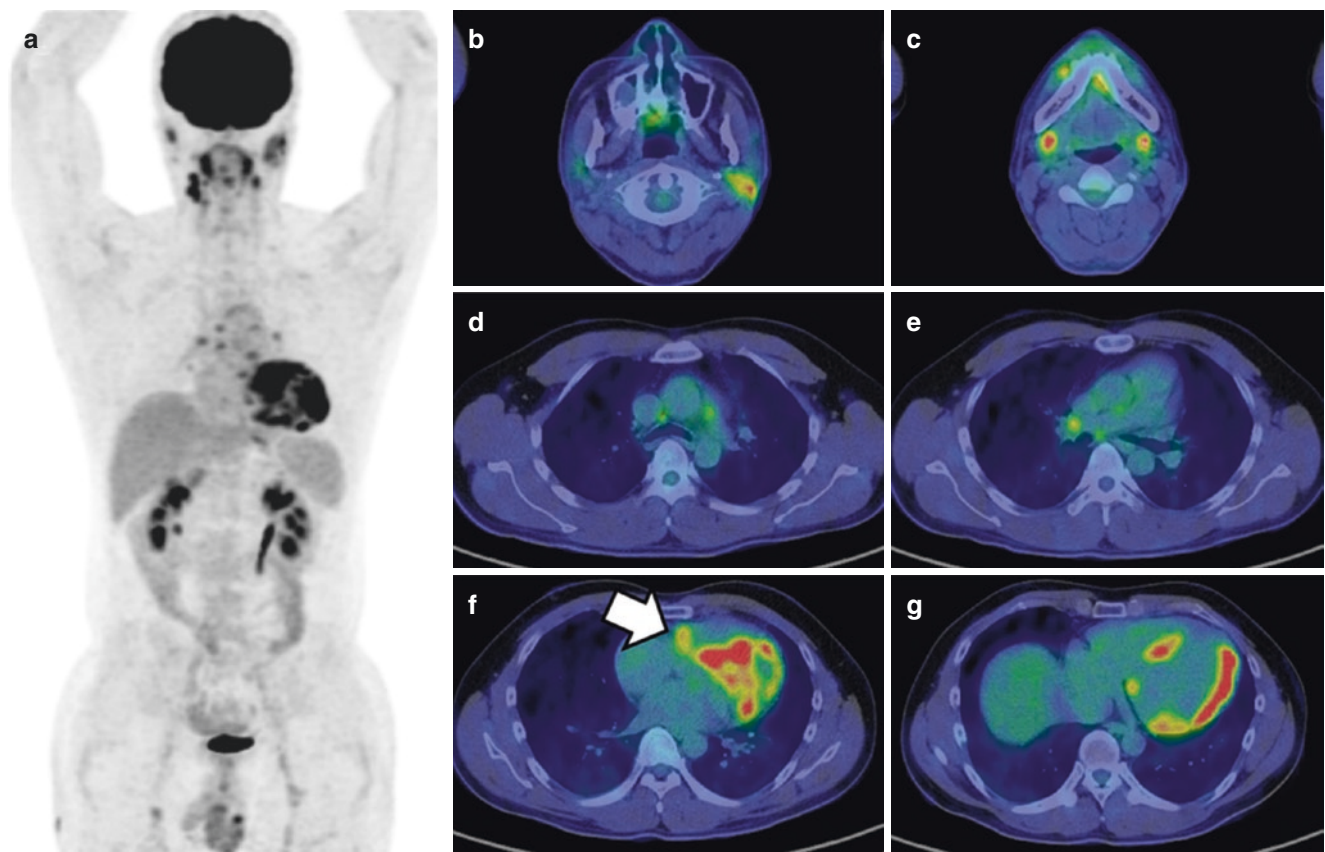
FDG PET/CT scan at the follow-up
